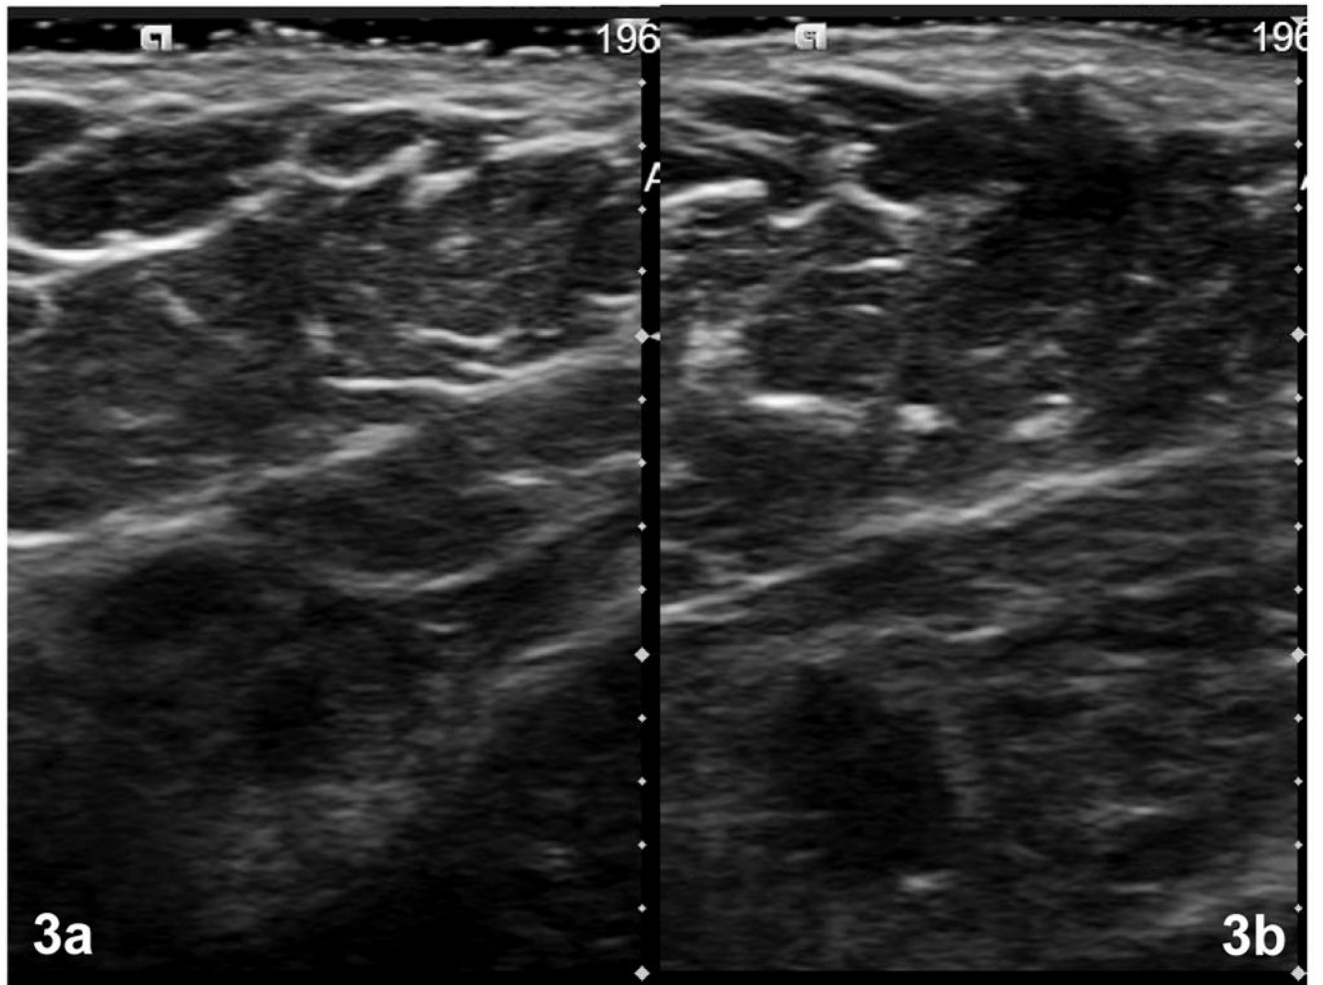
Ultrasound images of both axillae of a 42 year old woman (without the Jelco marker) showing no identifiable cord-like or other abnormal structures in either the affected side (a) or the unaffected side (b).
